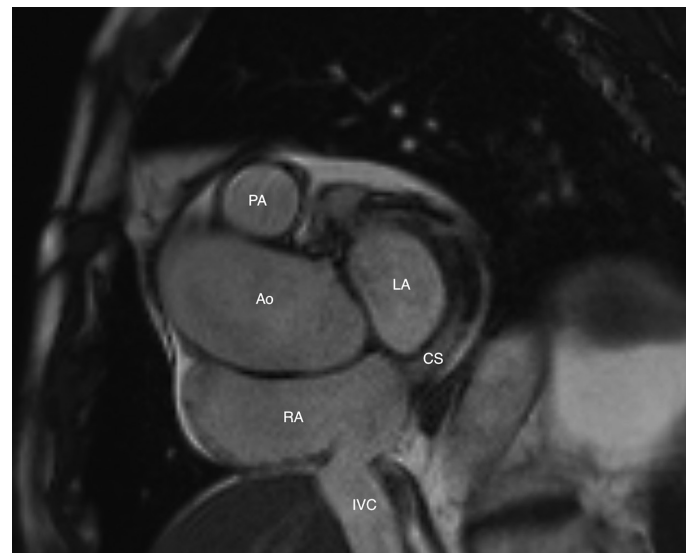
Cardiac MRI demonstrating normal coronary sinus draining into the right atrium. LA, left atrium; RA, right atrium; CS, coronary sinus; Ao, aorta; PA, pulmonary artery; IVC, inferior vena cava; MRI, magnetic resonance imaging.
